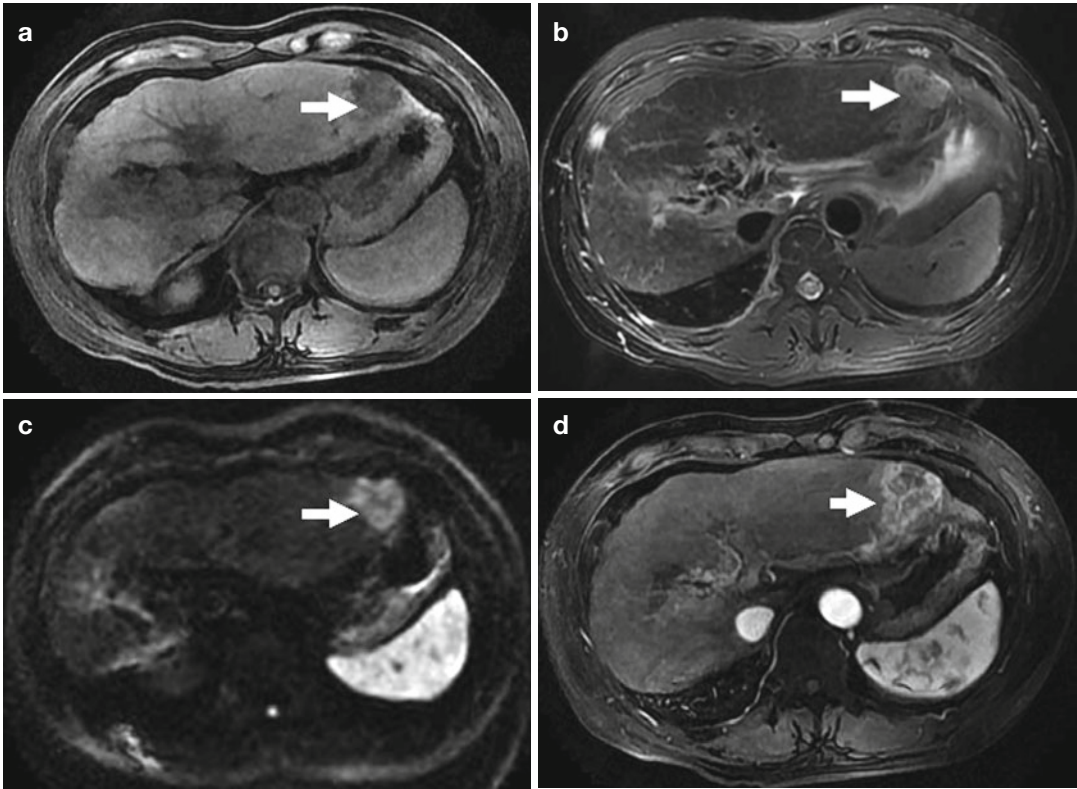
A 55-year-old man with a history of chronic hepatitis B, cirrhosis, and transcatheter arterial chemoembolization for HCC is found with a hepatic lesion (5 cm) located in the left lateral lobe and adjacent to stomach. The lesion is diagnosed to be HCC combined with history and contrast-enhanced images and treated with MWA and EA. (a) The hepatic lesion located in the left lateral lobe (*arrow*) is hypointense and adjacent to stomach on T1-WI MRI before treatment. (b) The hepatic lesion is hyperintense (*arrow*) on T2-WI MRI before treatment. (c) The
